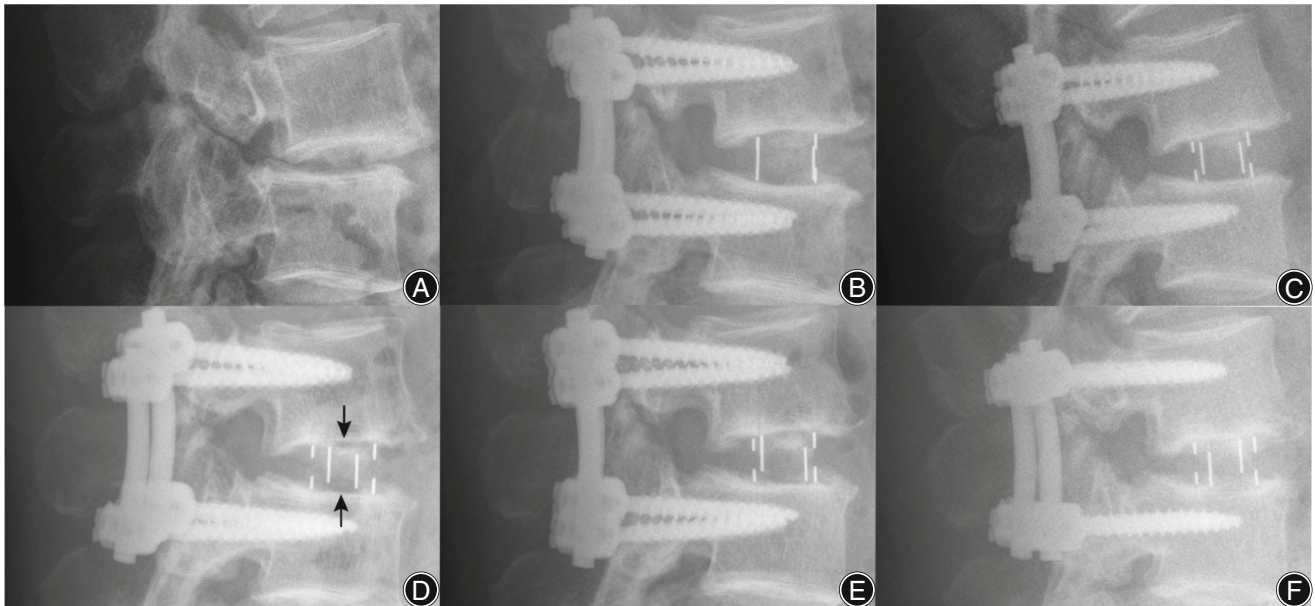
Lateral radiographic images of a 50-year-old male who had the operation at L3-4 level. (A) preoperative. (B) 1-day postoperative. (C) 3-month postoperative. (D) 6-month postoperative, Bridwell grade III fusion: non-continuous bony incorporation within the cage and definite lucency present at the top or bottom of the graft (arrows). (E) 12-month postoperative, Bridwell grade II fusion: bone not fully remodeled and incorporated, but no lucency present. (F) 24-month postoperative, Bridwell grade I fusion: continuous bone fused with remodeling and trabeculae
